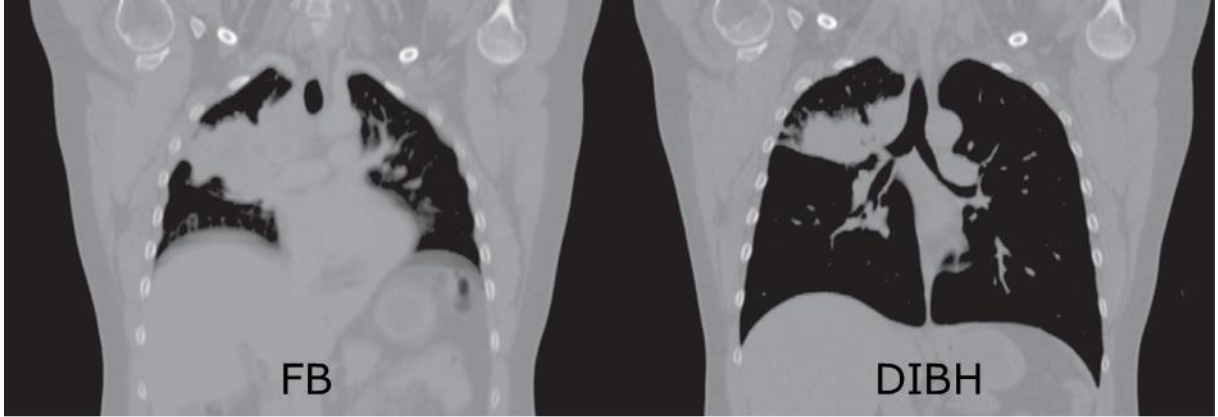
Coronal slices of a NSCLC patient CT scanned in both free-breathing (FB) and deep-inspiration breath-hold (DIBH). The increase in total lung volume for this patient was by Ottosson *et al.* observed to be 167% in DIBH (figure adopted with permission)[14].
